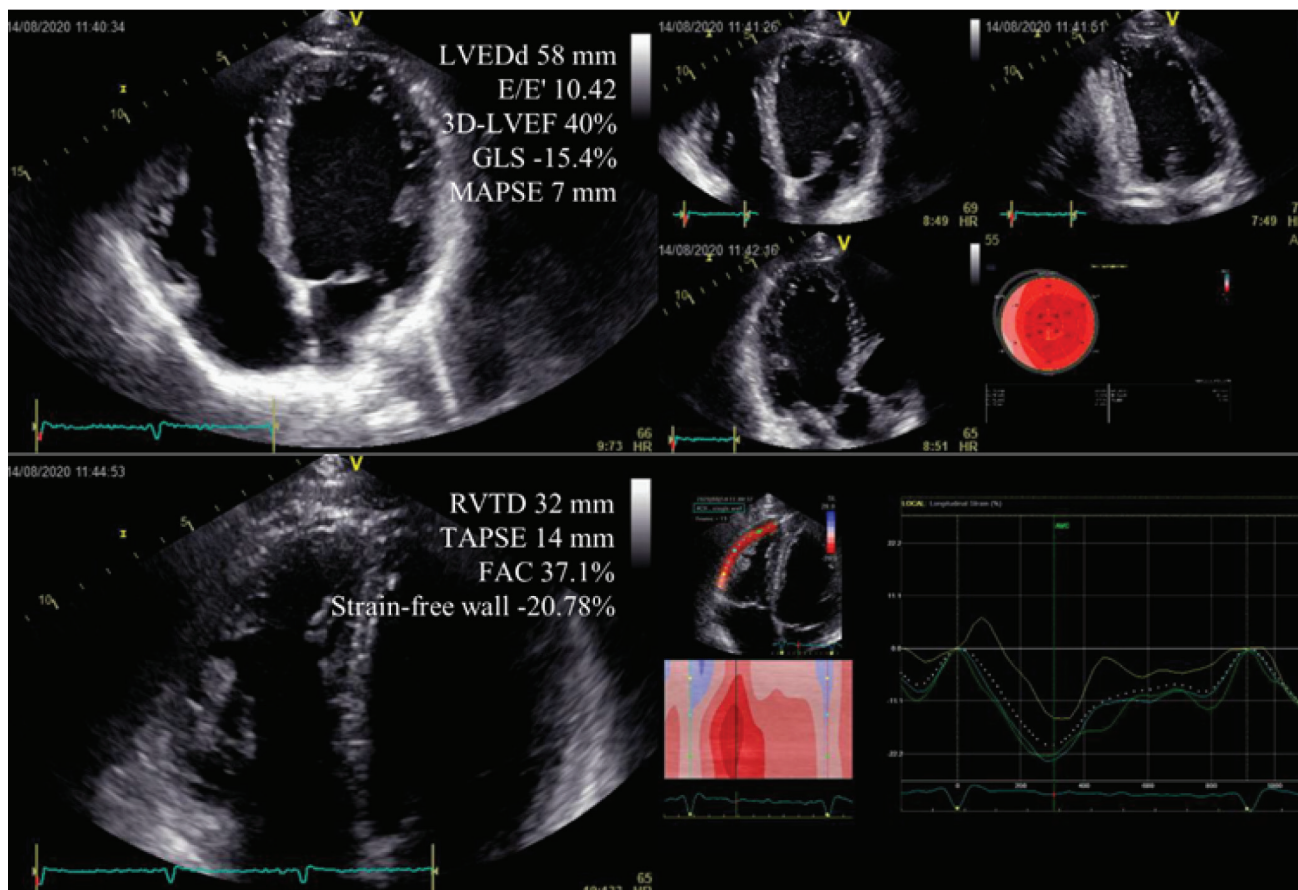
Echocardiographic assessment of anabolic steroid-induced cardiomyopathy. Representative echocardiogram images for the left ventricle (upper panel), and the right ventricle (lower panel) with corresponding values. Transthoracic echocardiography was performed using Vivid E95 Cardiac Ultrasound (GE Healthcare, Chicago, IL, USA).
